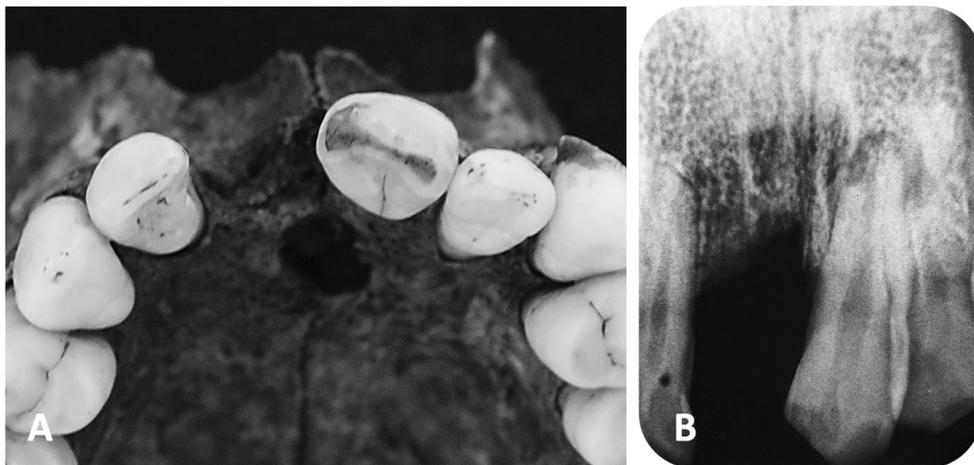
Occlusal view of the maxillary first left incisor (A) and segmented x-ray of the same tooth (B) revealed irregular loss of tooth substance with larger distal defect and root resorption.
